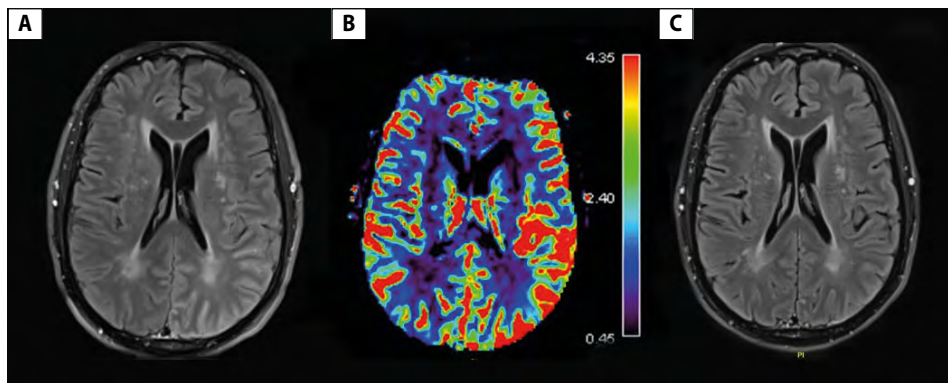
Brain MRI FLAIR (A) and perfusion imaging (B) three days into aura event, showing non-enhancing gyriform T2 signal intensity in left posterior temporal, parietal, occipital lobes, and relative hyperemia on perfusion imaging. Follow-up scan performed five weeks later (C) showed resolution of T2 signal changes
